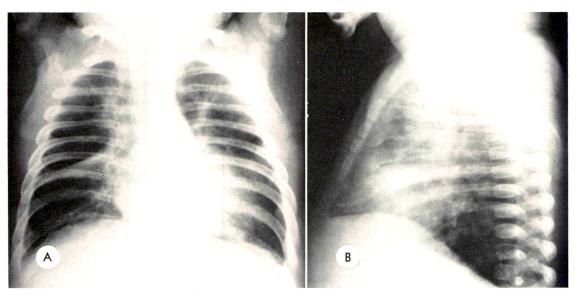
(A) Posteroanterior and (B) lateral roentgenograms of a boy with acute pulmonary infection show rather typical findings of bronchiolitis with right middle lobe atelectasis.
